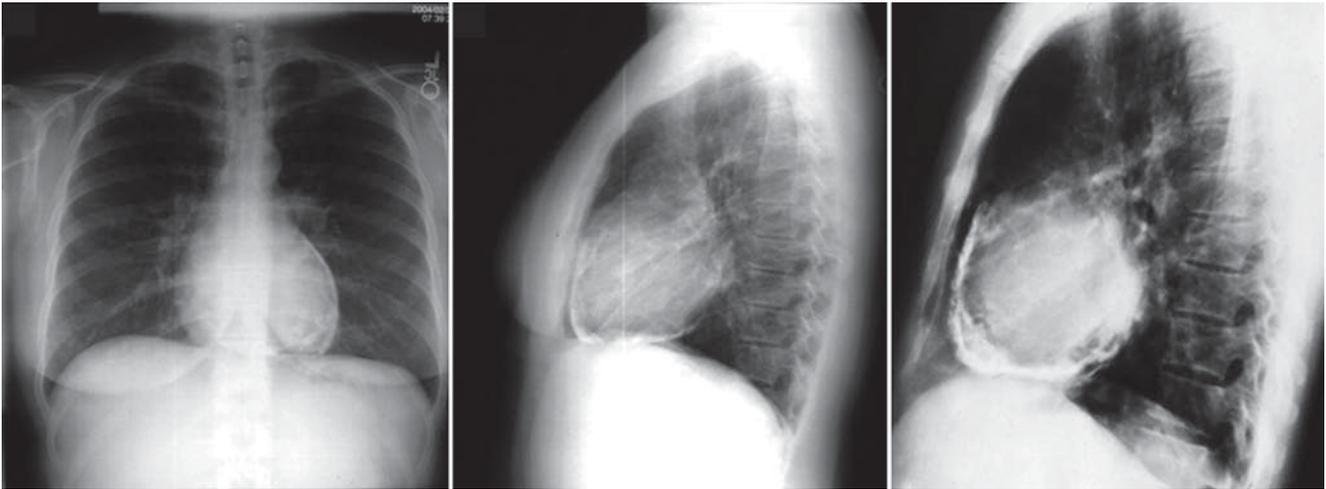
Pericardial calcifications on chest X-ray
